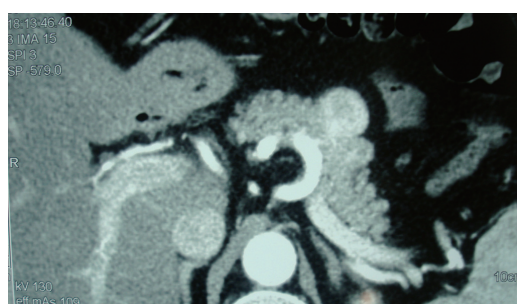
Computed tomography scan revealing a 3.9 cm exophytic mass, arising from the pancreatic body, which was enhanced from the arterial to portal venous phase.
